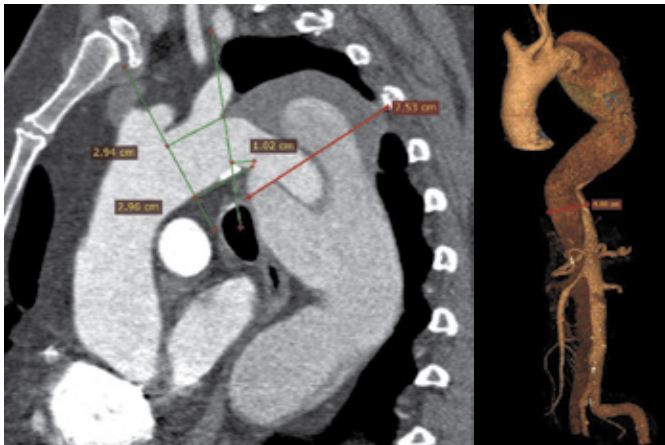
CTA showing a type B aortic dissection with the entry tear located at the inner curvature of the aortic arch, 1 cm below the origin of the left subclavian artery. The diameter of the descending thoracic aorta at the widest point was 7.5 cm, while the diameter of the middle and the lower third was 40 mm.
